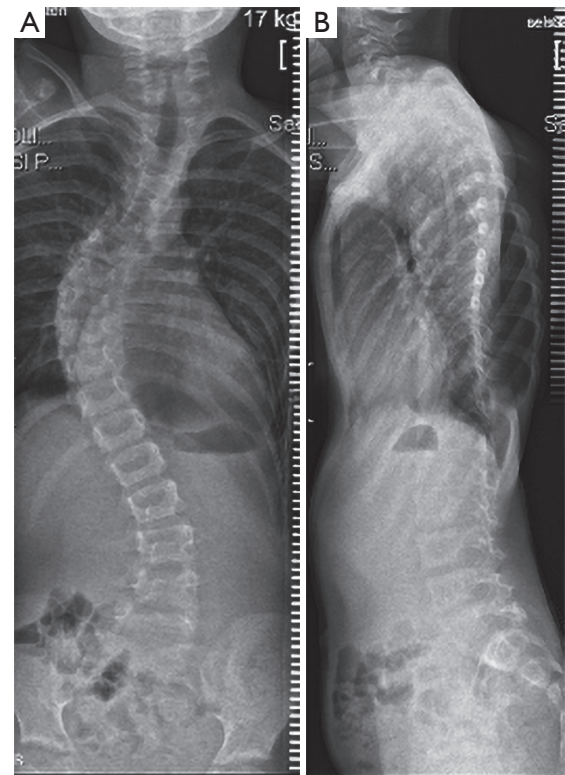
Two-year-old boy with syndromic 50-degree early onset scoliosis (Marfan syndrome). (A) Standing posteroanterior spinal radiographs before casting; (B) 1-year follow-up at the end of casting, radiograph taken in a brace.
